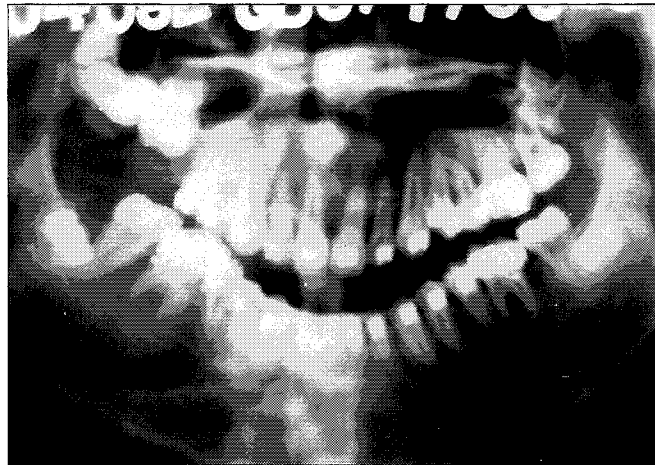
Case 13. An orthopantomogram showing a space distal to the upper right second premolar and the unerupted molars on the same side.
